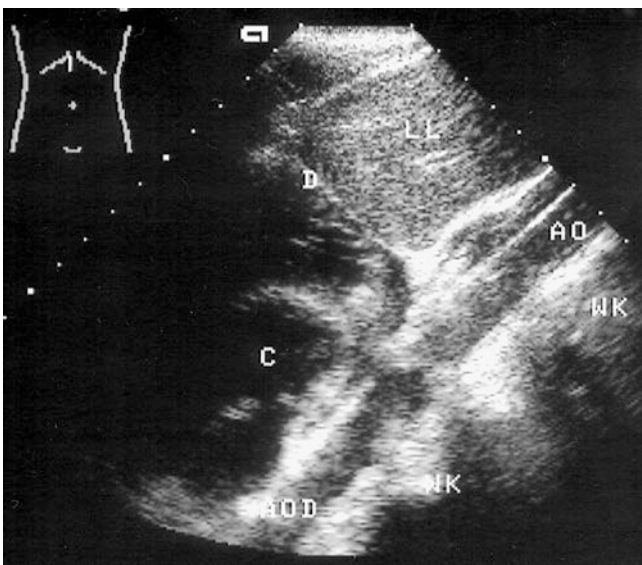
Infrasternal sonography. Sagittal section. The esophagus can be observed at the passage through the diaphragm (D) ventrolaterally to the aorta (AO). The descending aorta (AOD) is partly covered by artifacts. WK vertebral body, C cor
